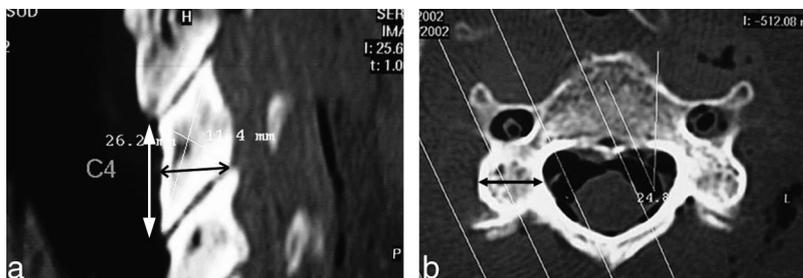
After the surgical anatomic study we could establish correspondences with landmarks on the CT scan. The SSA for Roy-Camille (a) was defined from the center of the posterior aspect of the lateral mass and limited by the nerve root groove superiorly and the tip of the lower lateral mass inferiorly. The SSA for Magerl (b) was defined from a point located 1 mm superiorly to the center of the posterior aspect of the lateral mass and limited by the upper lateral mass superiorly and the presence of the dorsal branch inferiorly. The dorsal
